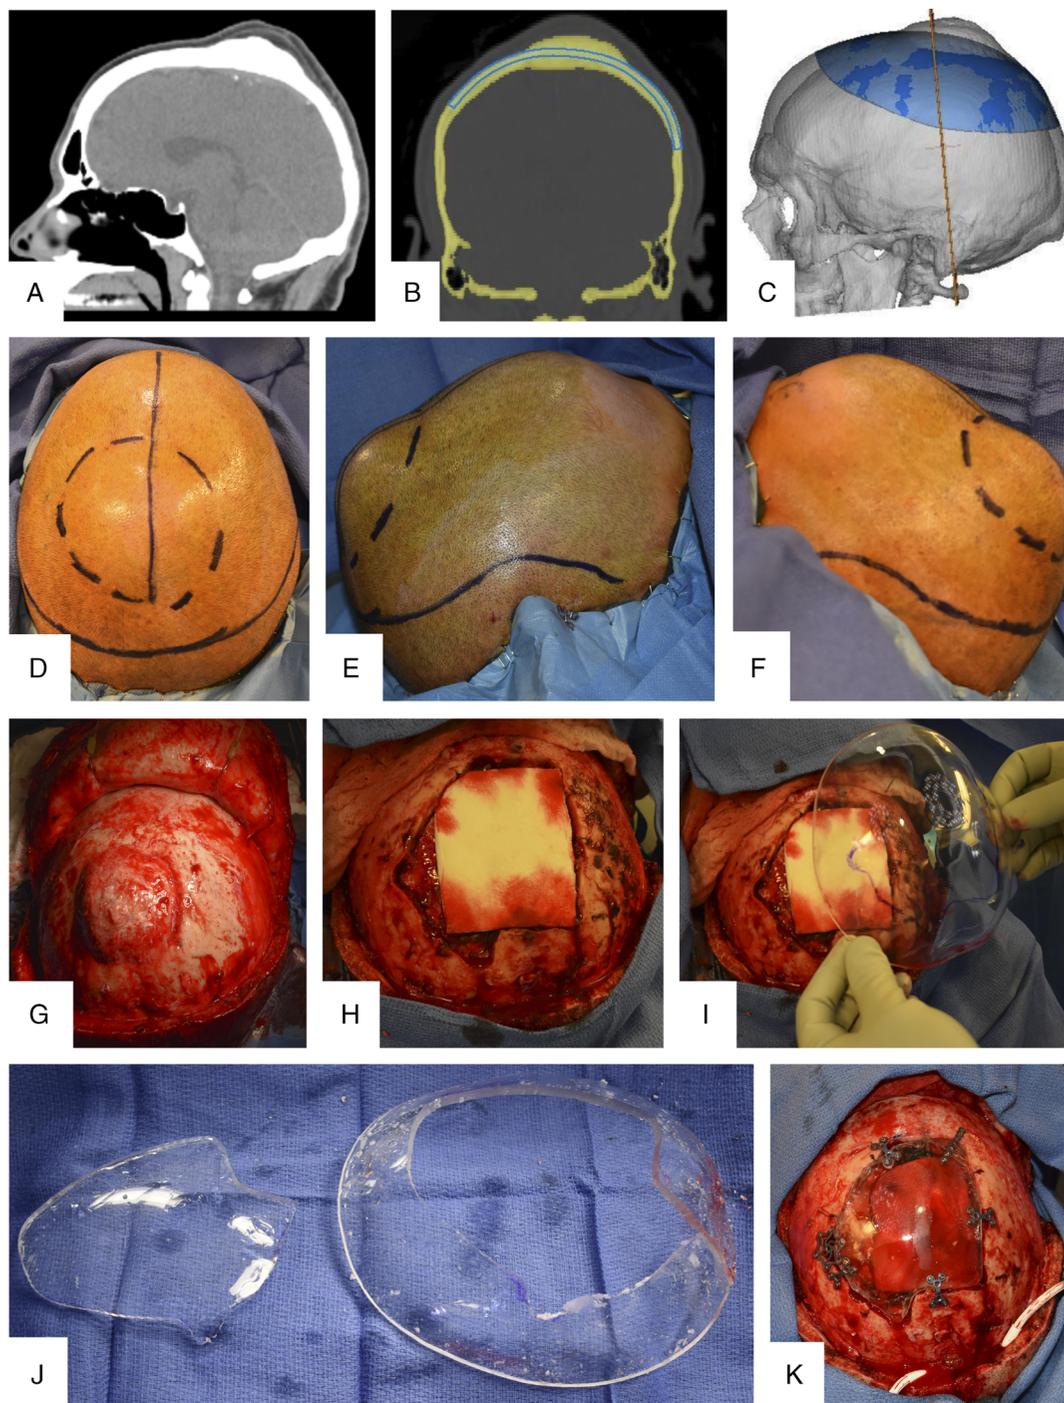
Single-stage cranioplasty for intraosseous meningioma resection. A, Lateral view of preoperative CT scan demonstrating large tumor with osseous involvement. B, virtual surgical planning image based on CT scan, coronal view. The bone is outlined in yellow, and the proposed customized implant is outlined in blue. Note that the blue implant model is purposely designed with a patient specific shape but horizontally extends well beyond the tumor size seen on preoperative imaging. C, Lateral view of 3D image used for 3D printing of the implant. The vertical line corresponds to the coronal cut-in (B). D–F, On table preoperative photographs showing horizontal (D) and lateral views (E, F) of the patient's head, with the face oriented to the top of the image in all photos. The dashed line outlines the palpable and visible tumor, and the sagittal midline is also marked. The incision for the bicoronal approach is also marked. G, Intraoperative photo showing tumor after bicoronal flap is dissected and elevated. H, Resultant defect after tumor resection, dural repair, and hemostatic collagen matrix is placed. I, The clear implant being placed over the defect, and a surgical marking pen used to outline the precise template. J, The surgeon uses a drill to intraoperatively cut the implant to the precise defect dimensions on the sterile back table. K, The implant is placed within the defect (note there is no overlap between implant and bone) and secured in place with titanium plates and screws. Surgical drains are placed, hemostasis assured, and meticulous multilayered scalp closure performed.
